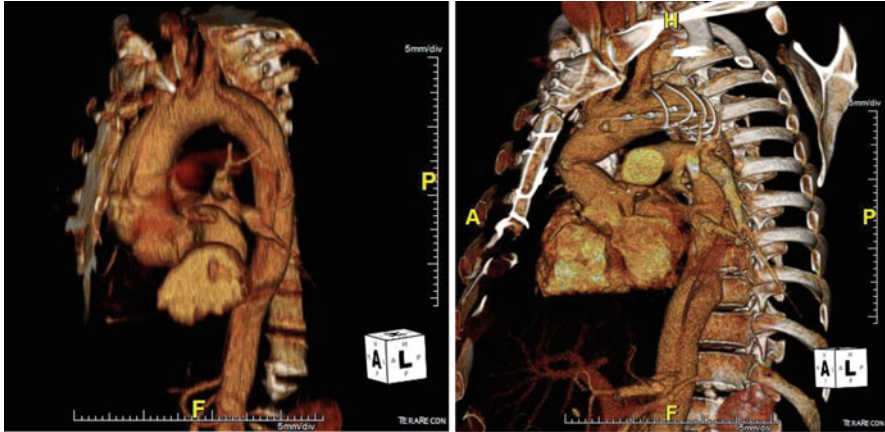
CT image of a patient with an acute type A aortic dissection pre- and postoperative after implantation of a hybrid stent graft in frozen elephant trunk technique
